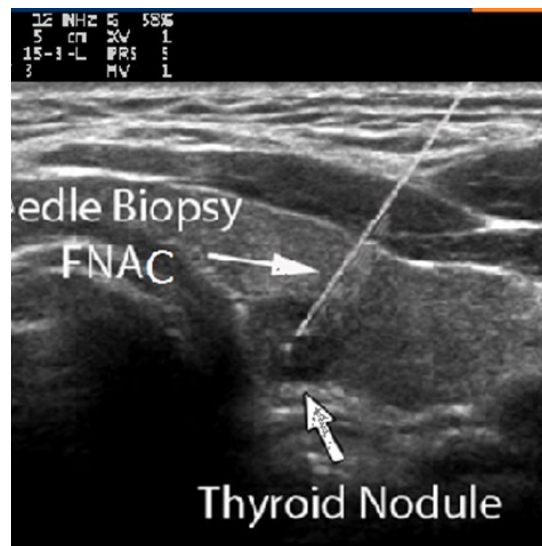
Figure showing ultrasound guided FNAC being performed
